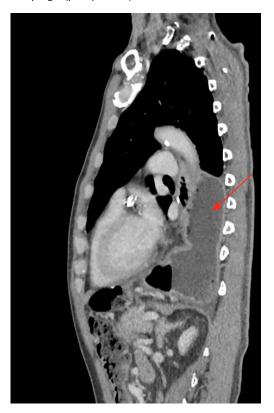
Sagittal view of CT scan showing the gastric pull up, stomach noted to be within the thoracic cage (post-operation)
